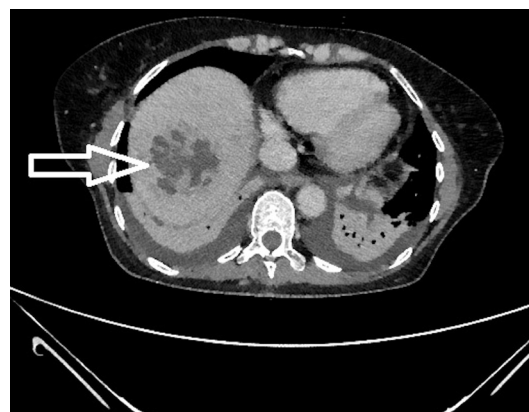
CT scan demonstrating a 5.5×4.8 x 3.7 cm multilobulated cystic lesion in the right lobe of liver consistent with a liver abscess. Bilateral lower lung consolidation and small pleural effusions were also noted.
